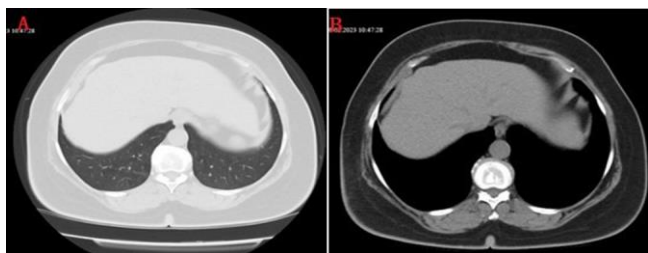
Postoperative 1st-year control computed tomography parenchyma window views (a) and mediastinal window views (b) show no recurrence
